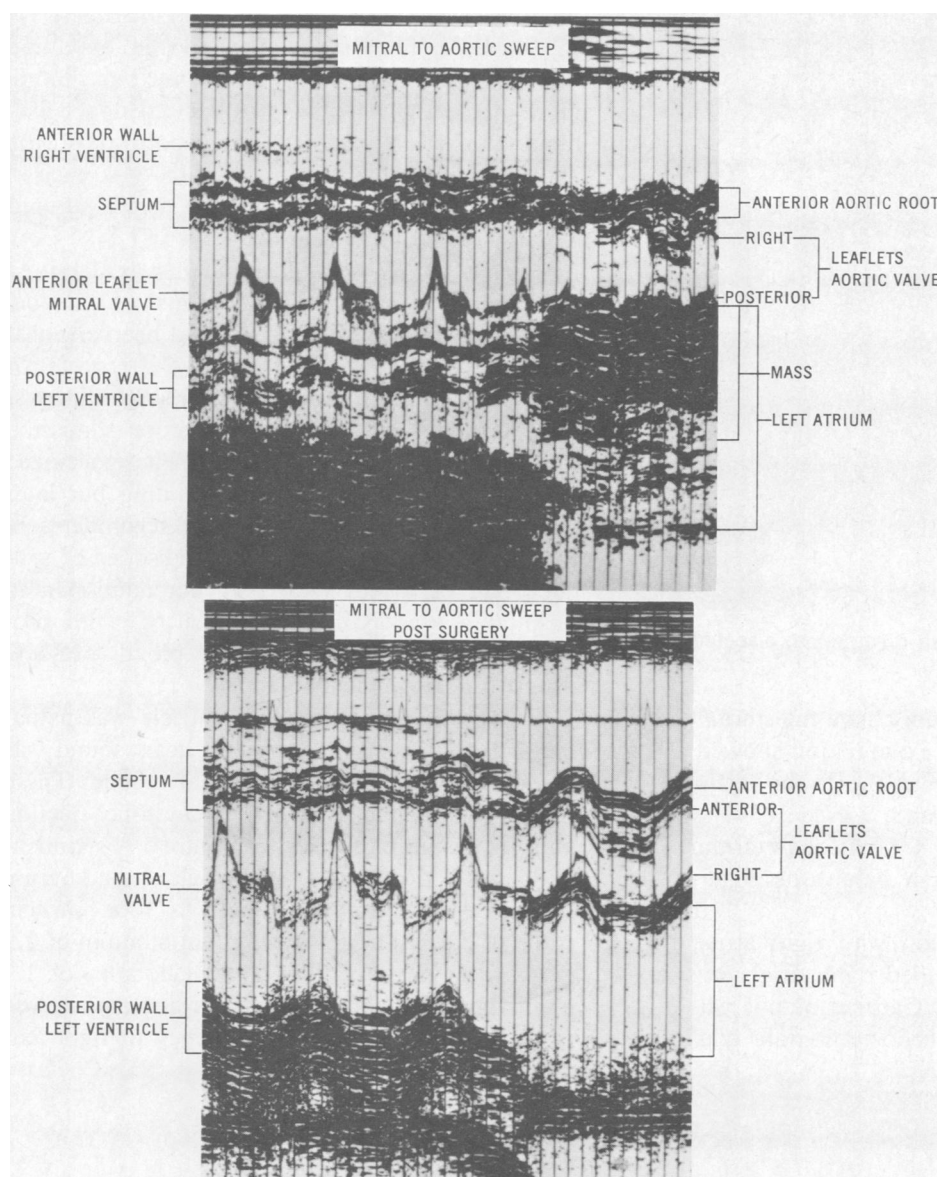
Preoperative and postoperative echocardiograms, case 5. Dense mass in the left atrium before operation is absent in the postoperative sweep.
